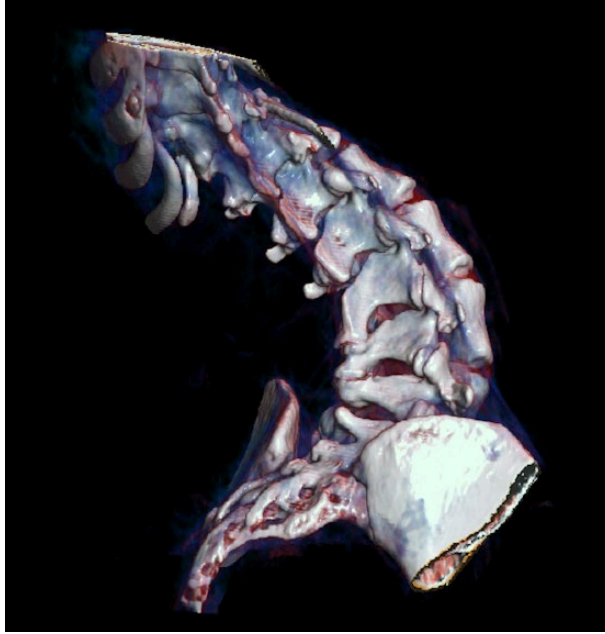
Three-dimensional computed tomography reconstruction in a volume rendering technique of a 44-year-old patient with SMA type 2 demonstrates the torsion of the scoliotic thoracolumbar spine, which complicates lumbar puncture for the intrathecal administration of nusinersen. SMA, spinal muscular atrophy.
